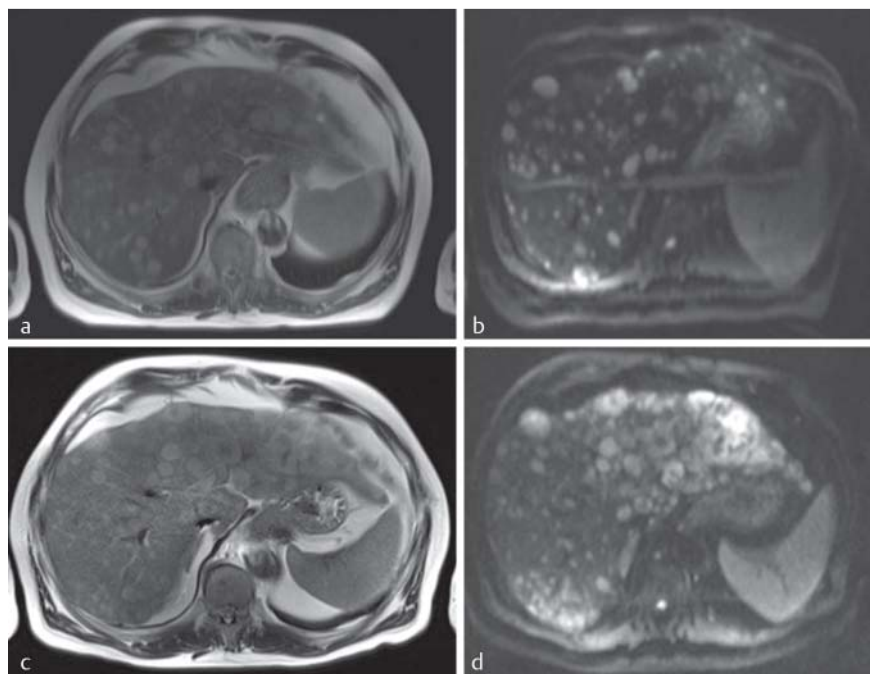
Magnetic resonance images (MRI) of a 64-year-old man with metastatic ocular melanoma a, b. Due to vascular abnormalities, only the right liver lobe was treated with a single chemosaturation-PHP treatment. The postoperative MRI scans c, d showed stable disease in the right lobe, whereas disease progression occurred in the left lobe. (a, c: T2-haste, b, d: T2-TSE).
